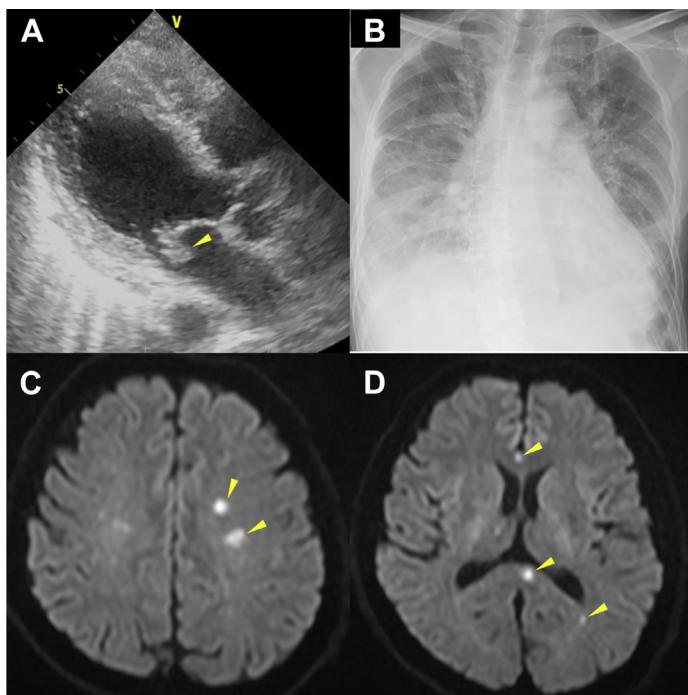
A case of mitral valve endocarditis complicated with multiple embolic stroke. A 57-year-old man with atopic dermatitis presented with a 3-day history of fever and malaise. Blood culture was positive for methicillin-susceptible *S aureus*, and he presented plantar petechiae. Transthoracic echocardiography revealed highly mobile vegetation (arrowhead) attached to the anterior leaflet of the mitral valve and severe mitral regurgitation (A). The patient developed acute pulmonary edema on the third day of admission. Chest radiography showed bilateral congestion (B). Cerebral MRI showed multiple bihemispheric acute ischemic lesions as hyper-intensity signals (arrowhead) in diffusion-weighted image sequences (C, D). The patient underwent emergent mitral valve replacement and developed no further neurologic complications after surgery.
